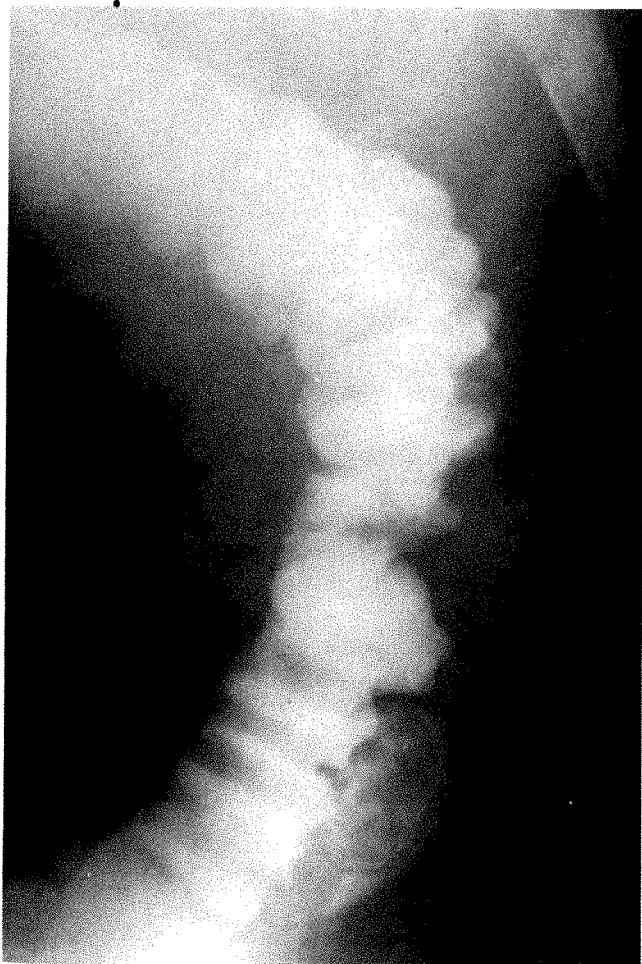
Anteroposterior roentgenogram obtained during barium enema. Radiodense mass seen lateral to descending colon.
